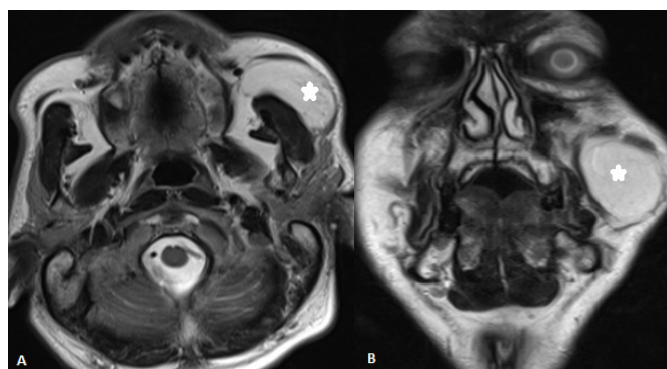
Axial (A) and coronal (B) MRI images of the buccal lipoma
